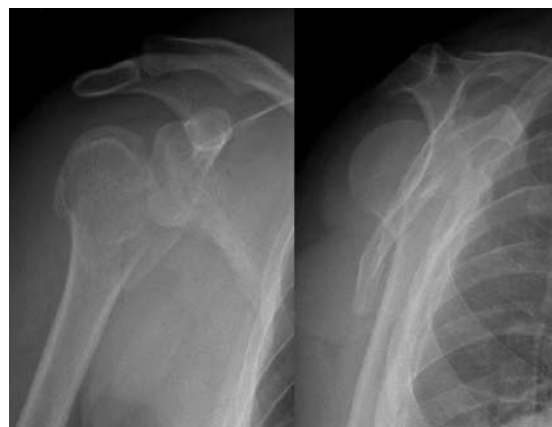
(a) Anteroposterior and (b) Y-scapular view radiographs of the right shoulder show a comminuted fracture of the humeral head and a concomitant posterior dislocation.
